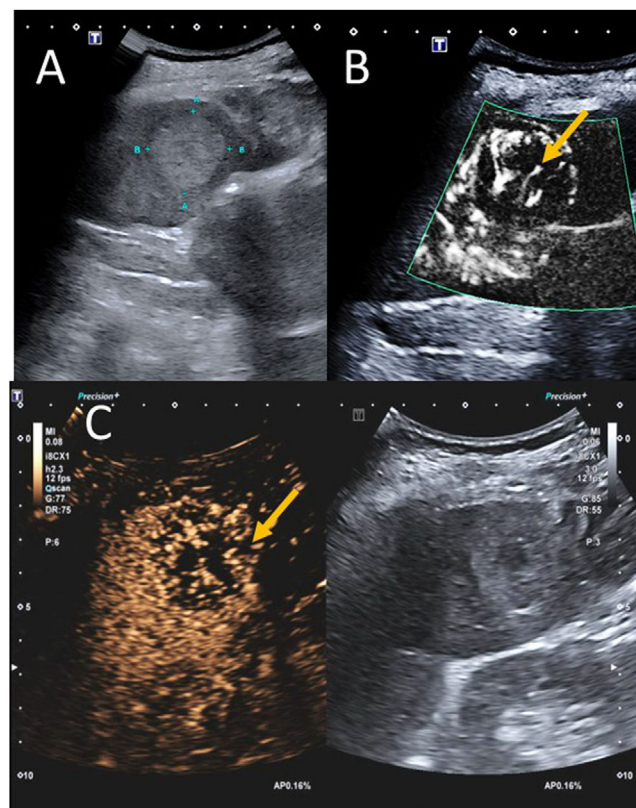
80-year-old male with advanced dementia. (A) Incidental finding of a solid, hyperechoic focal splenic lesion with a hypochoic centre, well-defined on baseline ultrasound (marked between cursors). (B) SMI (superb micro-vascular imaging) Doppler ultrasound, showing a vascular structure in the centre of the lesion (yellow arrow). (C) Arterial phase contrast-enhanced ultrasound at 15 seconds showing cartwheel uptake with radial arrangement and a central vessel. In this case, a sclerosing angiomatoid nodular transformation of the spleen was suggested as the most likely diagnosis and confirmed by an MRI scan (which we do not have). Due to the patient's age and different comorbidities (advanced dementia), the decision was made to manage without splenectomy.
